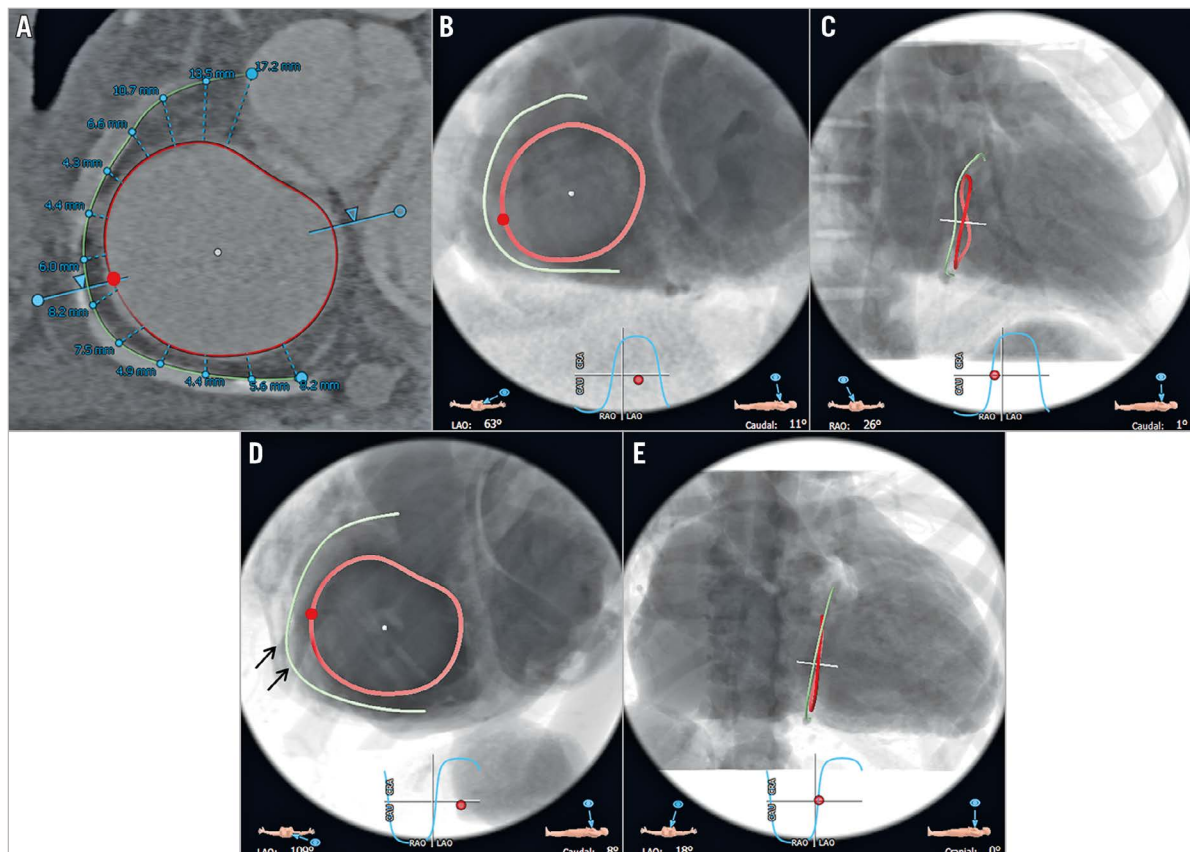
CT and fluoroscopic views of the TA and RCA in a control and a patient in diastole. CT (A) and fluoroscopic views of the TA and RCA in a control (B: 63° LAO; C: 26° RAO) and a patient (D: 109° LAO; E: 18° LAO) in diastole (80%), including distance measurements of 13 seed points in this representative patient (average number of seed points $n=10$). Red points: APC (B & D). Black arrows: short segment of the mid RCA in patients with consistent increase in distance to the TA (D), opposite the APC.
